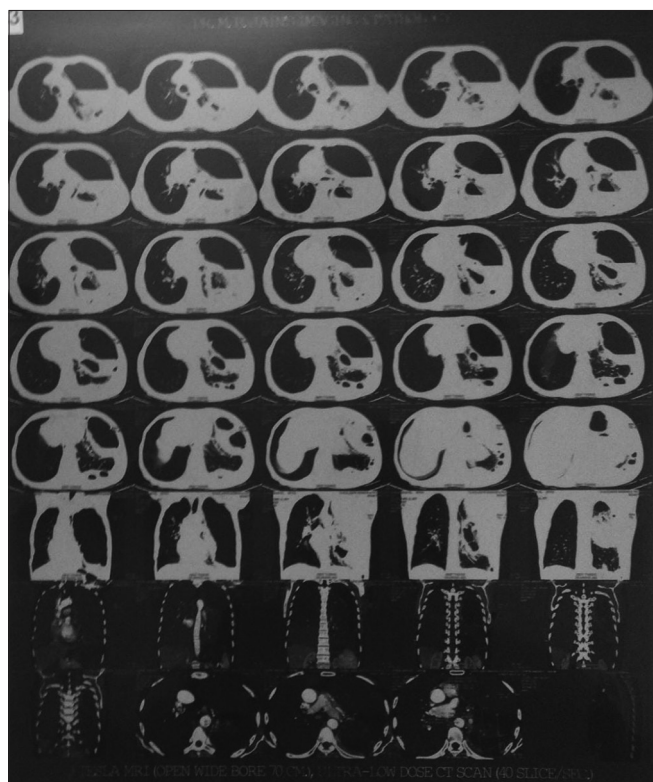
CT scan large left-sided hydropneumothorax with air-fluid level
